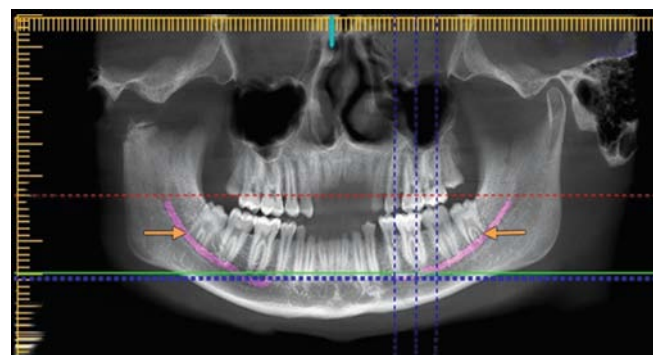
Tracing of inferior alveolar canal in panoramic section of CBCT
